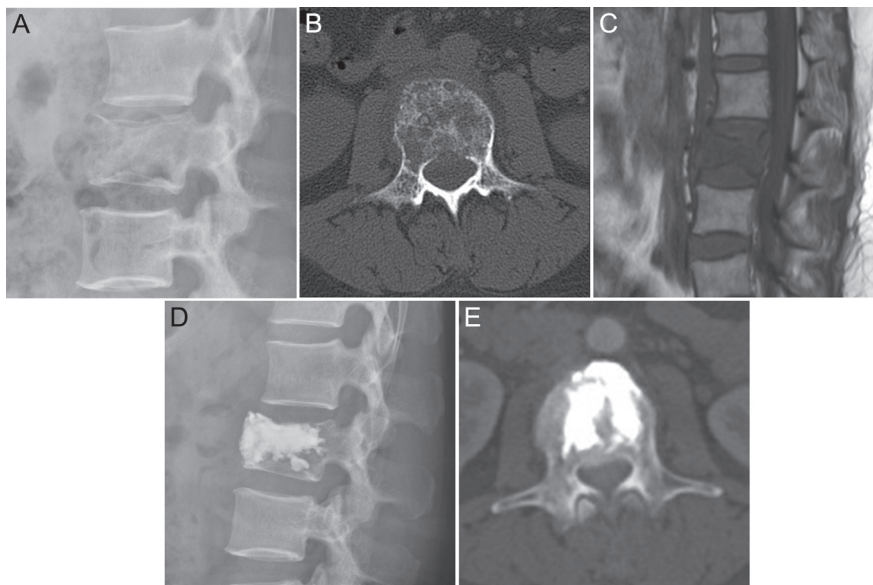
A-E. (A) Preoperative lateral radiograph showing a metastatic spinal compression fractures of L3. (B) Preoperative CT images showing bone destruction in the L3 vertebral body. (C) Preoperative magnetic resonance image (T1-weighted sequences) showing bone destruction in the L3 vertebral body. (D) Postoperative lateral radiograph after PMCP surgery. (E) Postoperative CT images showing good distribution of cement in the L3 vertebral body without leakage. CT, computed tomography; PMCP, percutaneous mesh-container-plasty.
